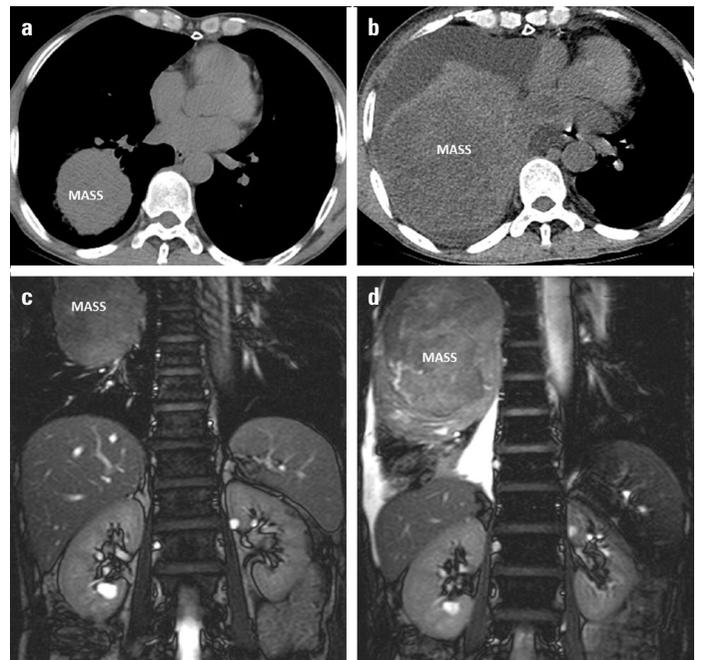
The CT and MRI images. The tumor in the lower right lung is significantly larger (a and c) than it was 8 months ago (b and d)
